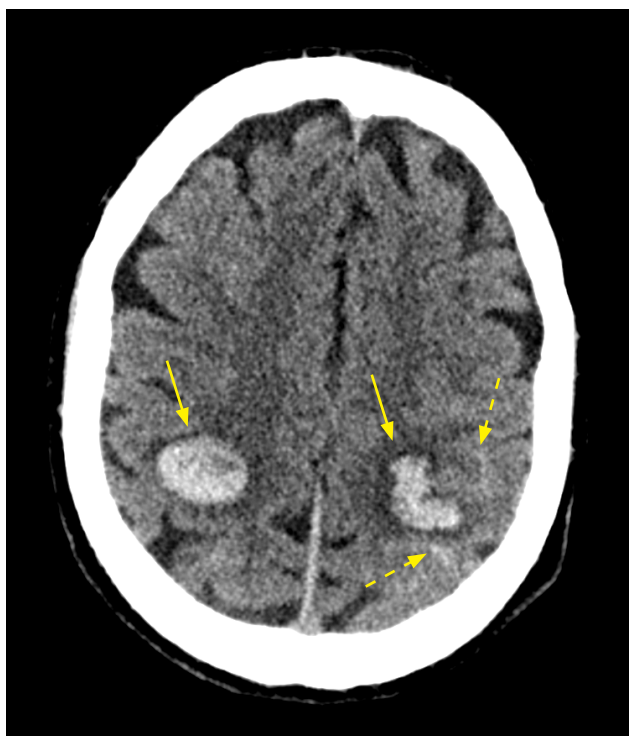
Axial non-contrast CT. Image demonstrating bilateral parenchymal haemorrhages (solid arrows) with a small amount of subarachnoid haemorrhage on the left (dashed arrows)
